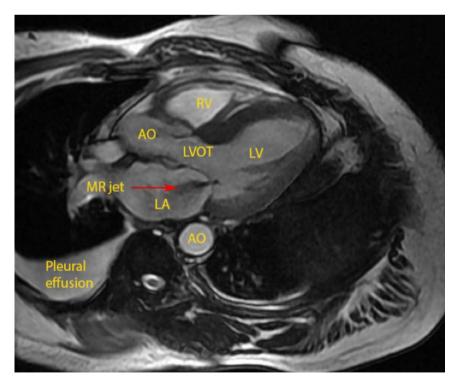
Role of cardiac MRI in mitral valve regurgitation [32]
